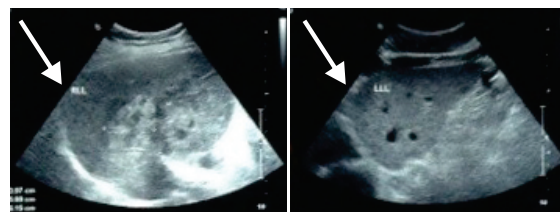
Abdominal ultrasonography showed multilobulated mass in homogen hyperechoic in right lobe of liver (arrow sign)
